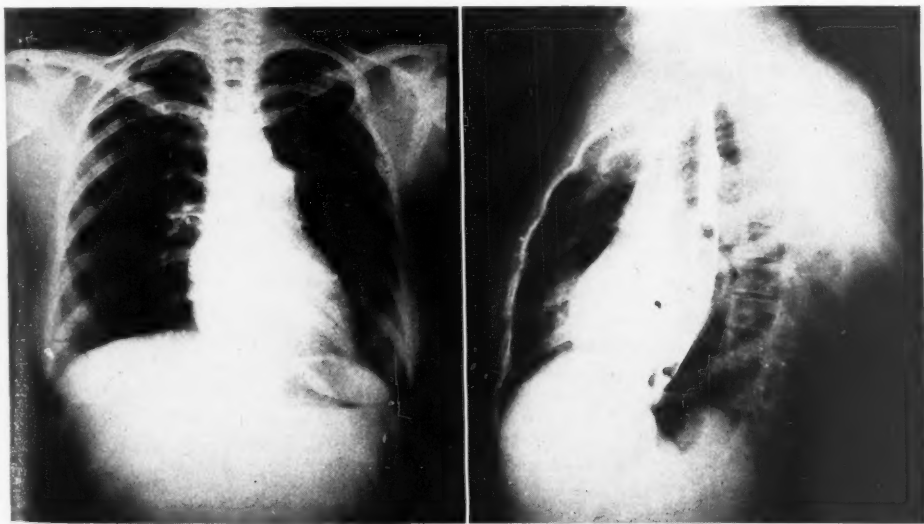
Anteroposterior and right anterior oblique roentgenograms made six months postoperatively showing reduced size of heart and left auricle and disappearance of pulmonary vascular congestion (Case 1).
